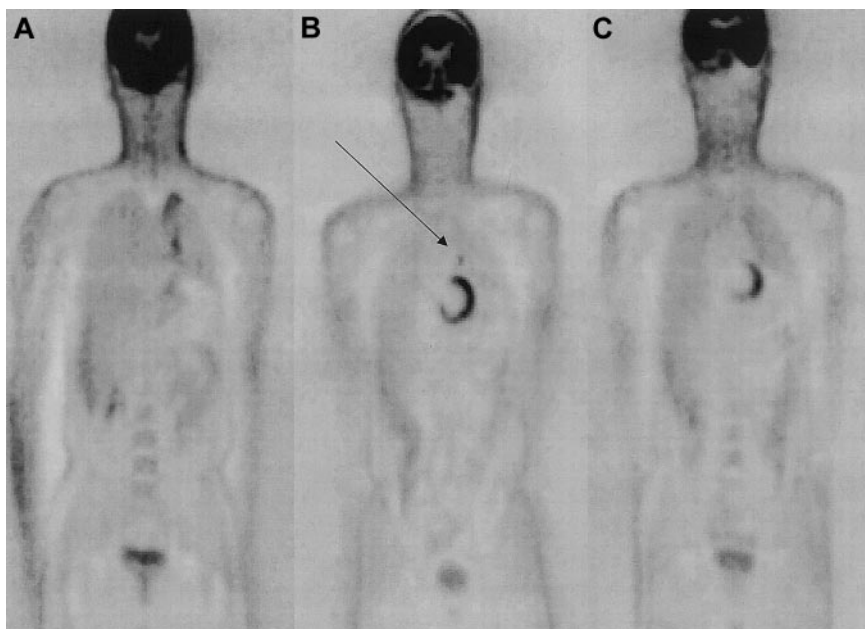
Example of a false-positive study. Pretransplantation [^{18}F]FDG-PET scan in a patient with nodular sclerosis HD showed residual [^{18}F]FDG uptake parahilar after radiotherapy (arrow). After HDT/SCT, the patient remained in CR (follow-up, 1464 days). (A) Scan before the start of treatment; (B) scan before transplantation; (C) scan after transplantation.
